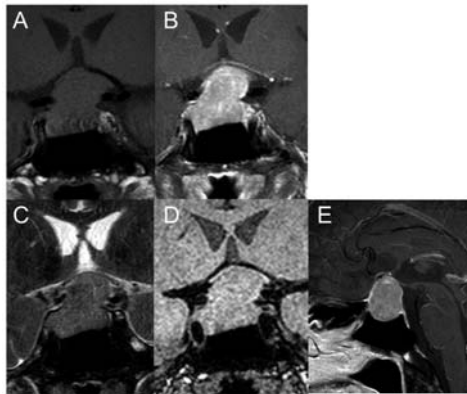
MRI findings of the pituitary adenoma patient. A-D; Coronal views of the pituitary adenoma. (A: T1-weighted image, B: With Gadolinium, C: T2-weighted image, D: Diffusion preparation image). E; Sagittal view (T1 with Gd). The MR images showed heavy pressure on the optic chiasm.
